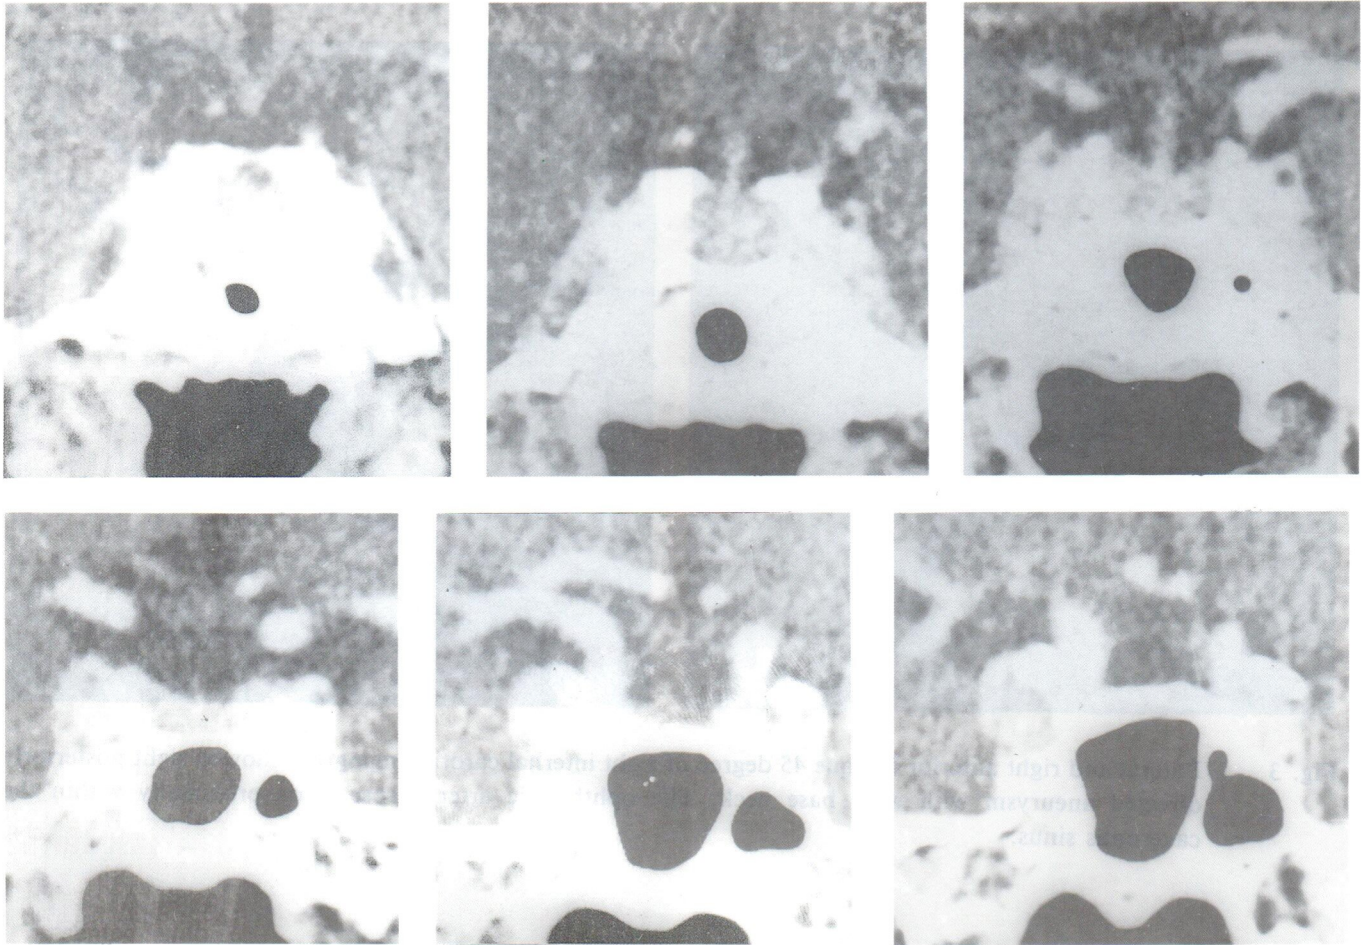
An outpouching of the right cavernous sinus was noted at coronal enhanced CT scan.
